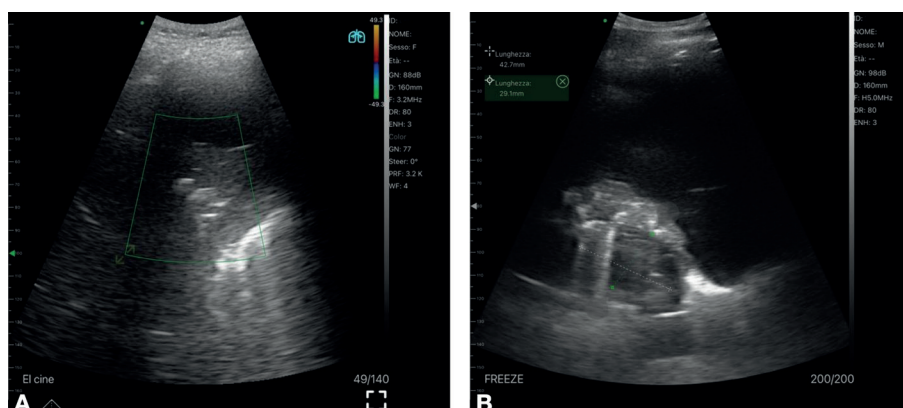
Hypoechoic consolidation in elderly with cough, but no fever; no vascularization at colordoppler examination: final diagnosis was pneumonia (a): hypoechoic consolidation in elderly with cough, but no fever; no vascularization at colordoppler examination: final diagnosis was lung cancer (b).
